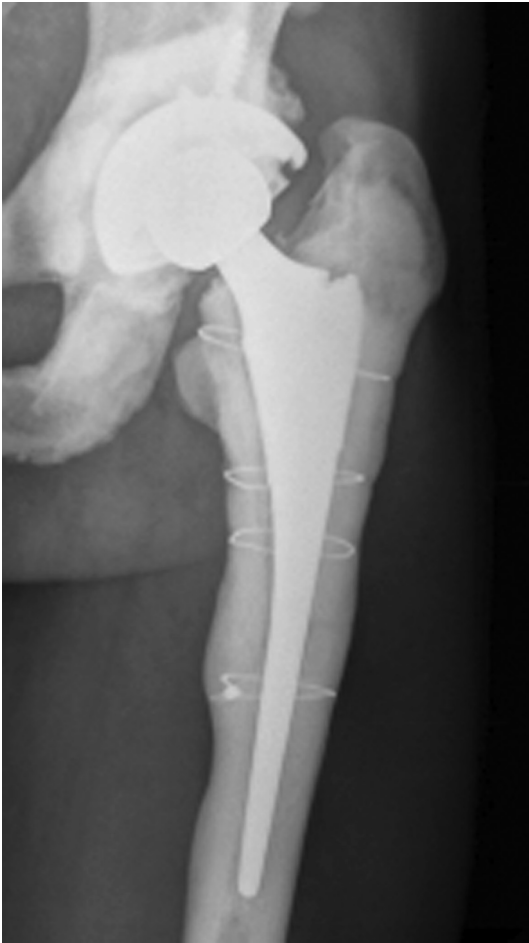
AP radiograph of pelvis showing a satisfactory fracture union and stable prosthesis at 10 years follow-up after the periprosthetic fracture.
